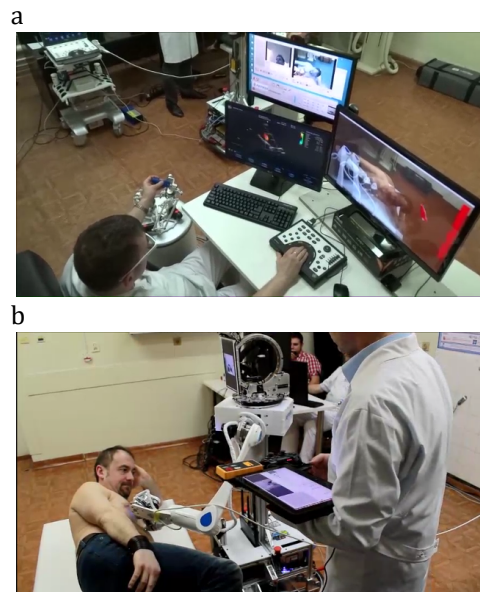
Integrated ReMeDi system (allowing remote ultrasound examination and palpation: a – DiagUI, b – robot ReMeDi)
